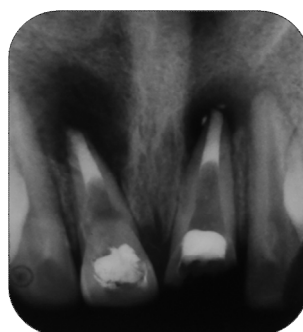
Preoperative radiograph Fig. 8 Apical 3-4mm MTA plug Fig. 9 Postobturation radiograph
